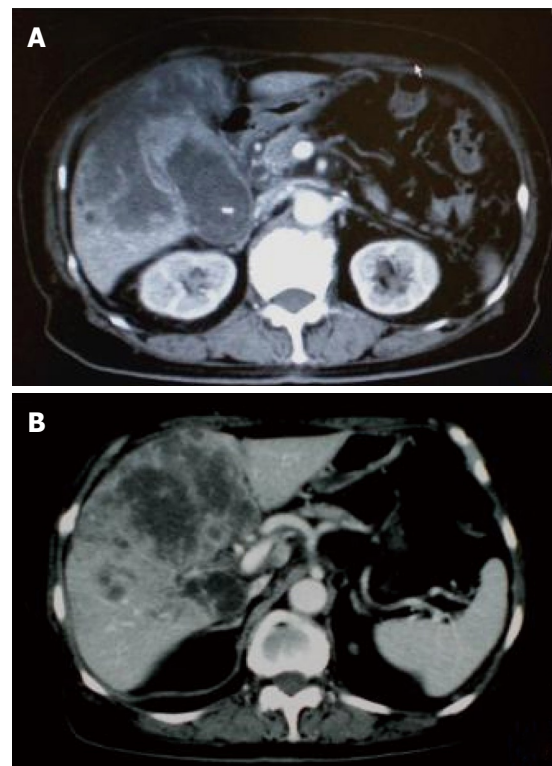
CE-CT after the end of 4 cycles of i.v. administration chemotherapy showed that the tumor increased in size. A: The GB tumor; B: Liver tumor.
